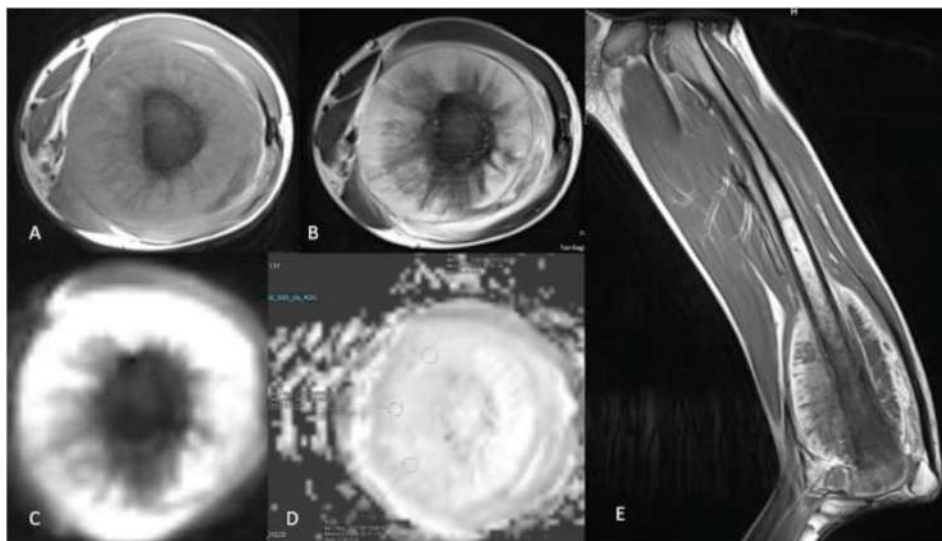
A 14-year-old male patient with chondroblastic type of osteosarcoma distal left femur. On MRI examination showed solid mass which appears isointense on axial T1 FSE (A), slight hyperintense on axial T2 FSE (B) and coronal T1 TSE fatsat with contrast showed contrast enhancement (E). Restricted diffusion area on DWI and slight hypointense on ADC maps (C, D) with mean ADC value of $2.27 \times 10^{-3} \text{ mm}^2/\text{s}$.
